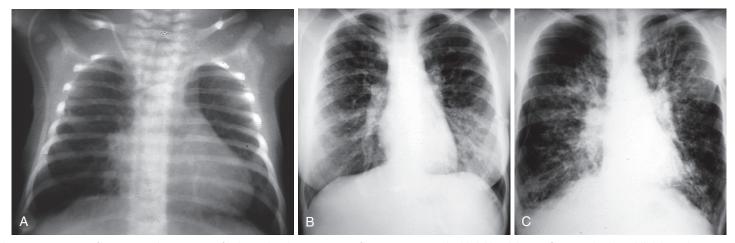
Cystic fibrosis. Typical progression of radiographic changes in cystic fibrosis. A, A 2-month-old child with hyperinflation and right middle lobe atelectasis. B, A 15-year-old girl with peribronchial cuffing, hyperinflation, and bronchiectatic changes, particularly of the lower lobes. C, A 21-year-old man with severe respiratory involvement and an unsuspected right pneumothorax.
